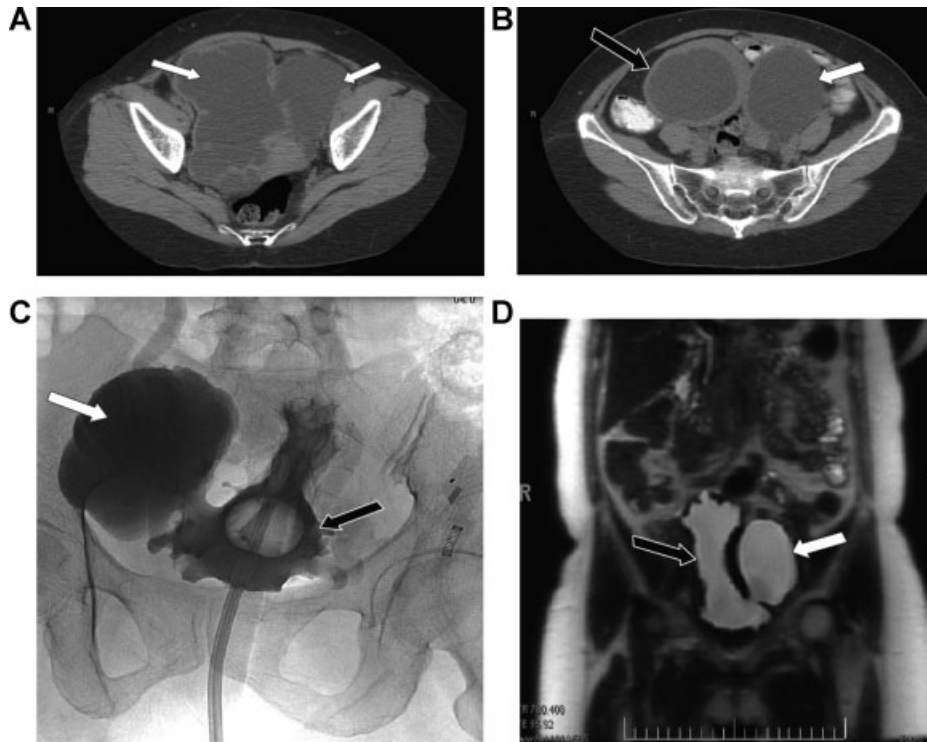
Woman with bladder outlet obstruction. All white arrows indicate multiple bladder diverticula black arrows indicate bladder. A&B CT scan of pelvis, C cystogram, D MRI of pelvis.
